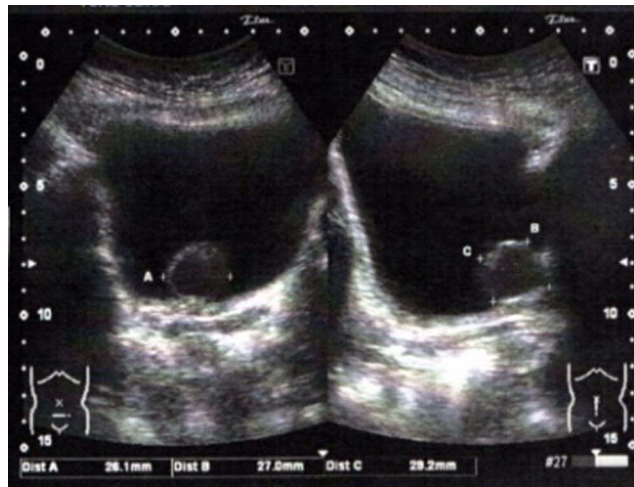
Abdominal ultrasound shows a neoplasm in the urinary bladder.
